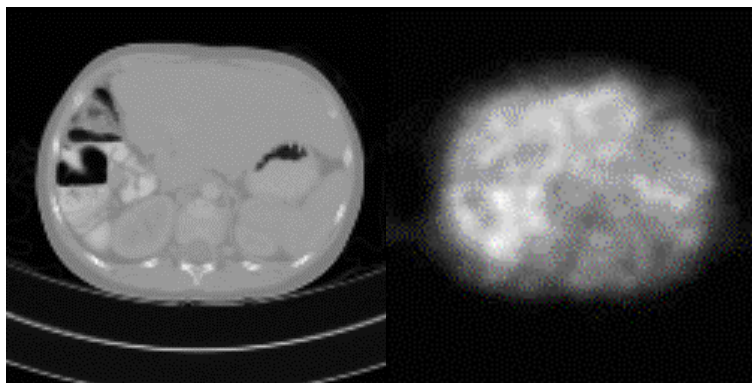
A typical CT (left) and ^{18}F -fluoro-deoxyglucose (FDG) PET (right) scan of a transverse slice through the abdominal region of a body. (Images courtesy of Children Hospital, Westmead)
